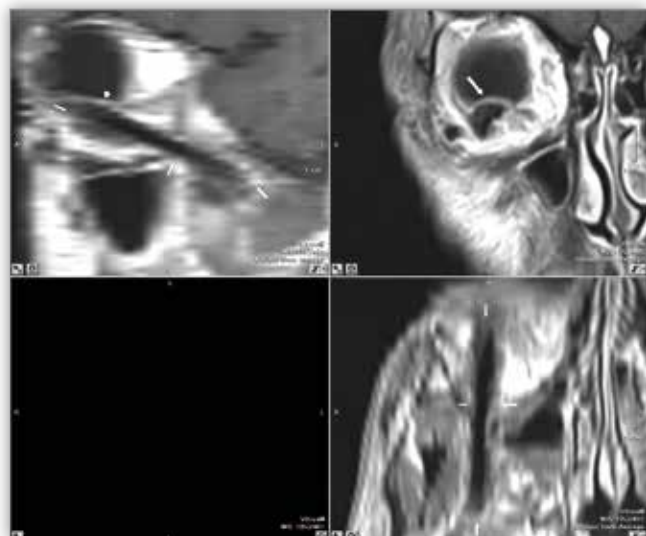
MRI the deformation of the eyeball bruised by a foreign body.
